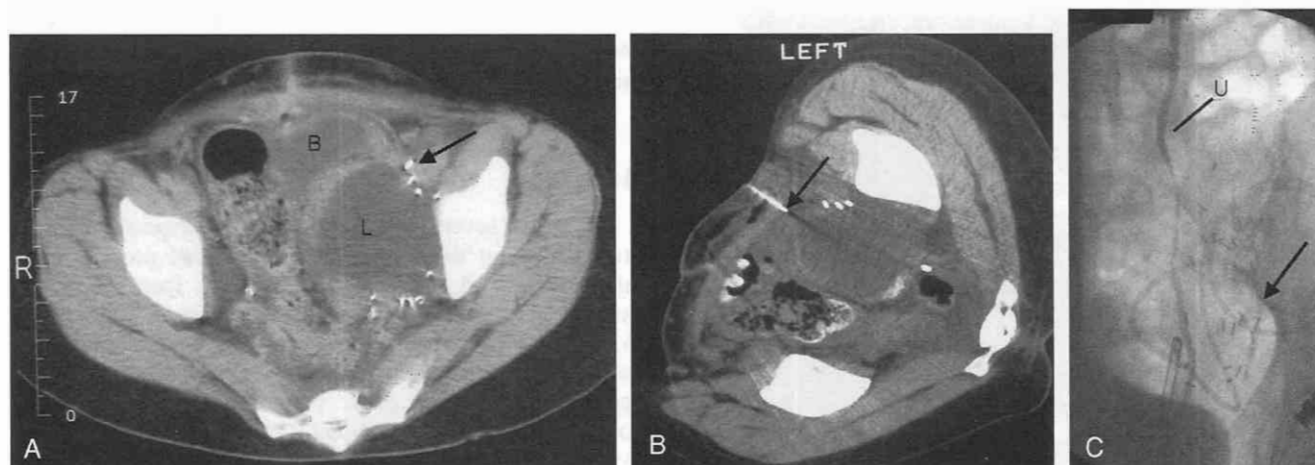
A, A large lymphocele (L) is noted in the left side of pelvis following kidney transplant. Access to the collection is impaired because of the proximity of bladder (B) and the clips from surgery. B, Positioning of the patient with the right side down increases the space for the needle trajectory (arrow) so the cyst can be punctured without penetration of the bowel or bladder, which could potentially introduce infectious agents. C, Radiograph shows the catheter in the lymphocele (arrow) and the ureter (U).
